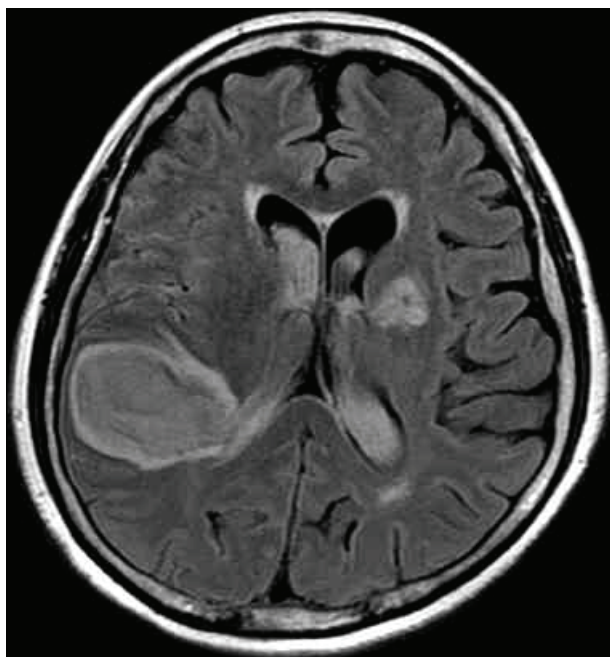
Magnetic resonance imaging (MRI) of the brain. There is acute intracerebral hemorrhage in the right temporoparietal lobe, with intraventricular hemorrhage.
